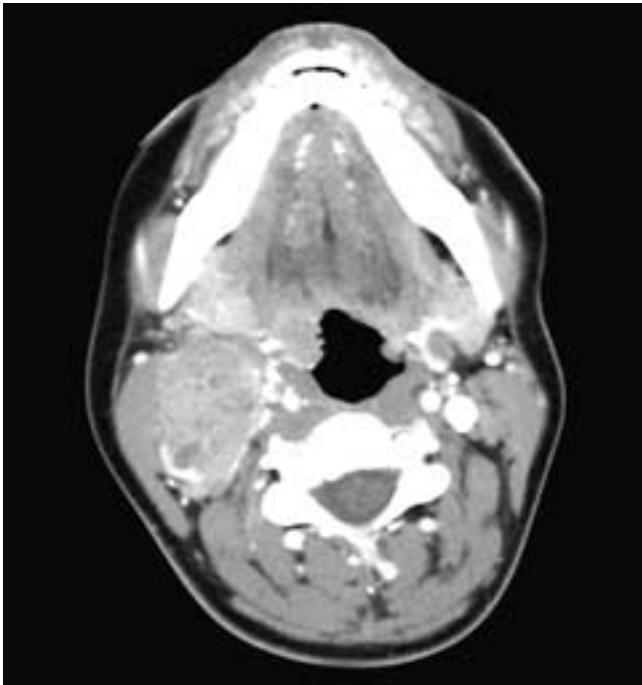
Axial contrast-enhanced CT scan shows prominence of the right palatine tonsil and an enlarged, slightly nonhomogeneous right level II node. There is no involvement of the adjacent fat planes in this patient with large cell lymphoma.
